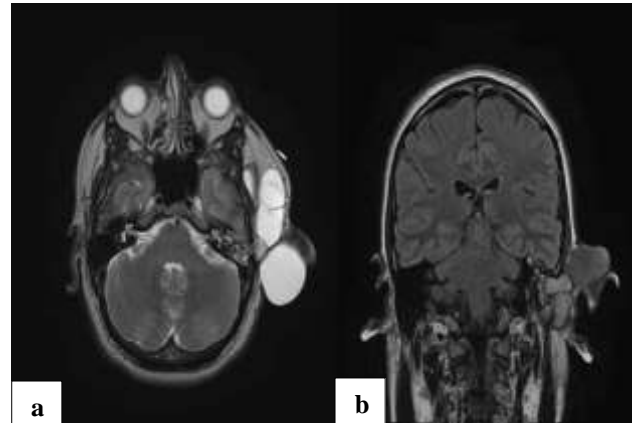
Preoperative MRI findings, (a) T2 axial image, and (b) T1 coronal image.
